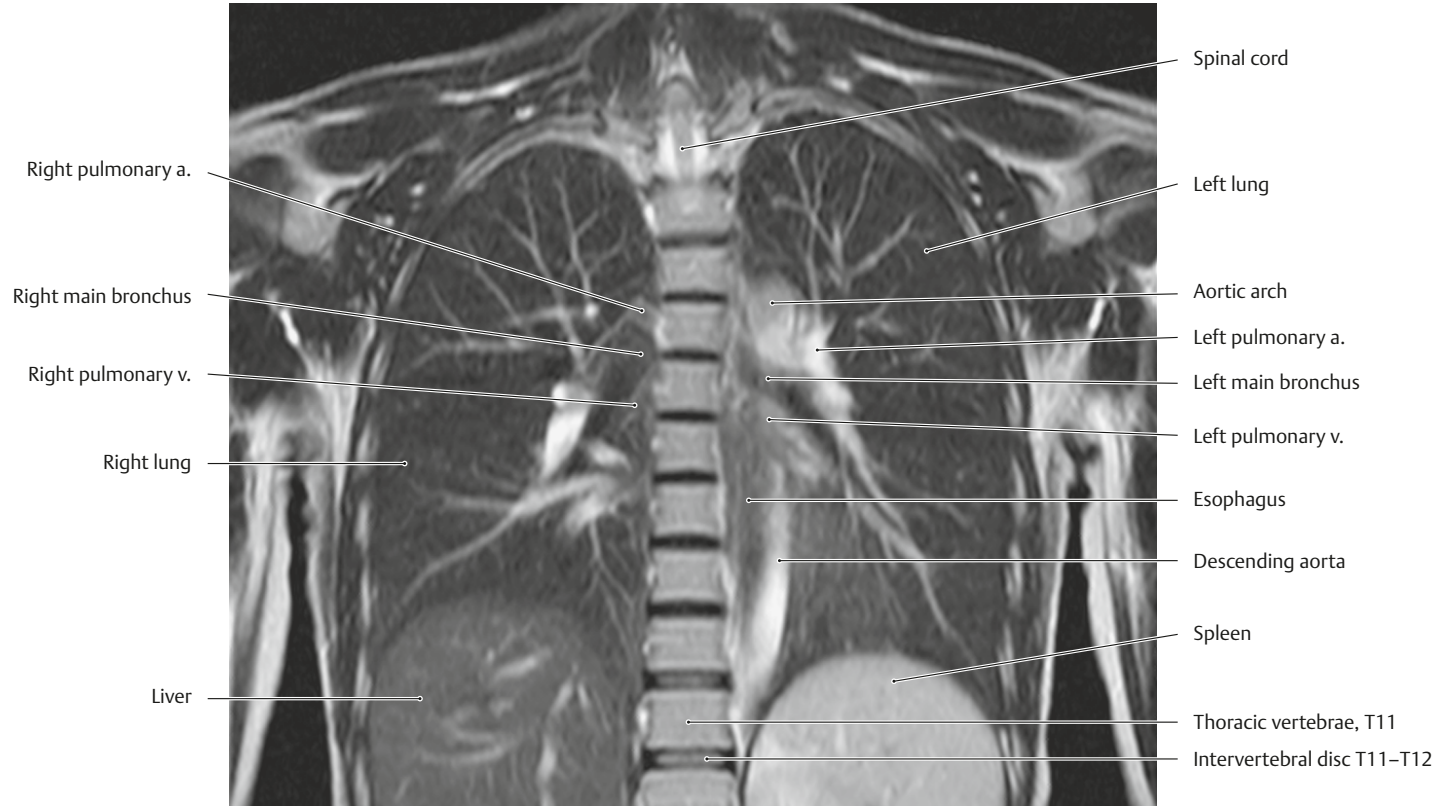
MRI of the thorax
